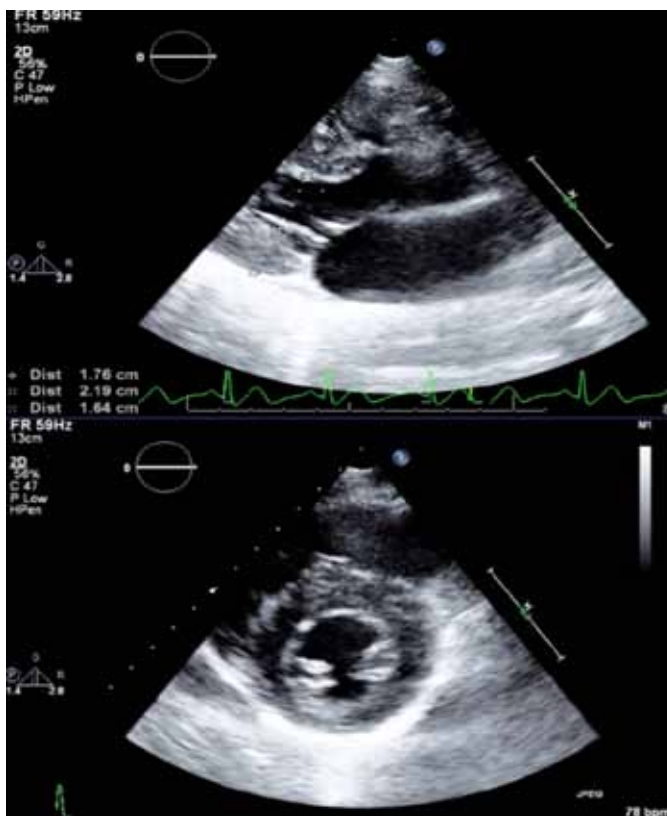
Echocardiography showing hypertrophic cardiomyopathy.
